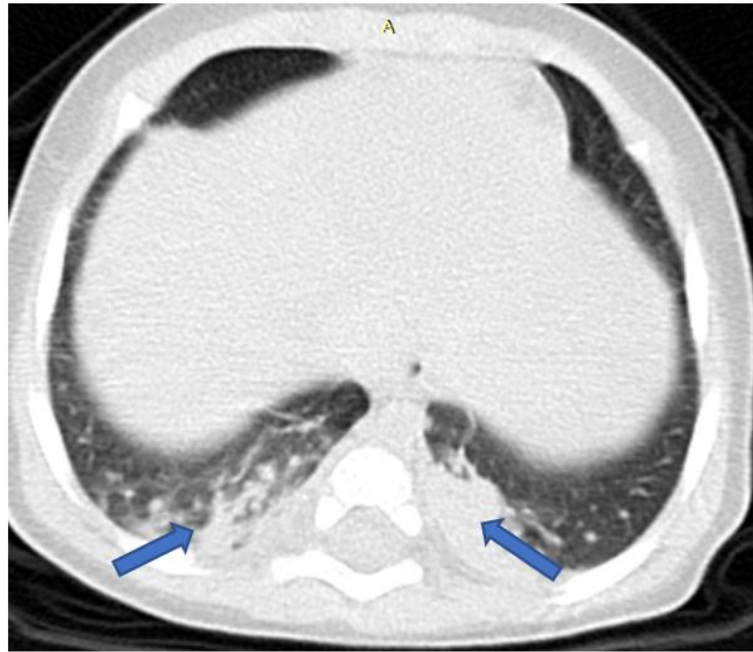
Axial CT images showing bilateral foci of consolidation in the posterior region (blue arrow).
